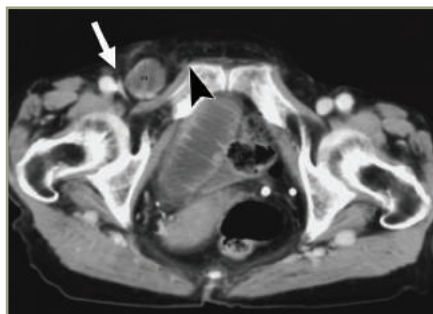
CT shows a femoral hernia located medial to the compressed femoral vein (white arrow) and lateral to pubic tubercle (arrowhead).
